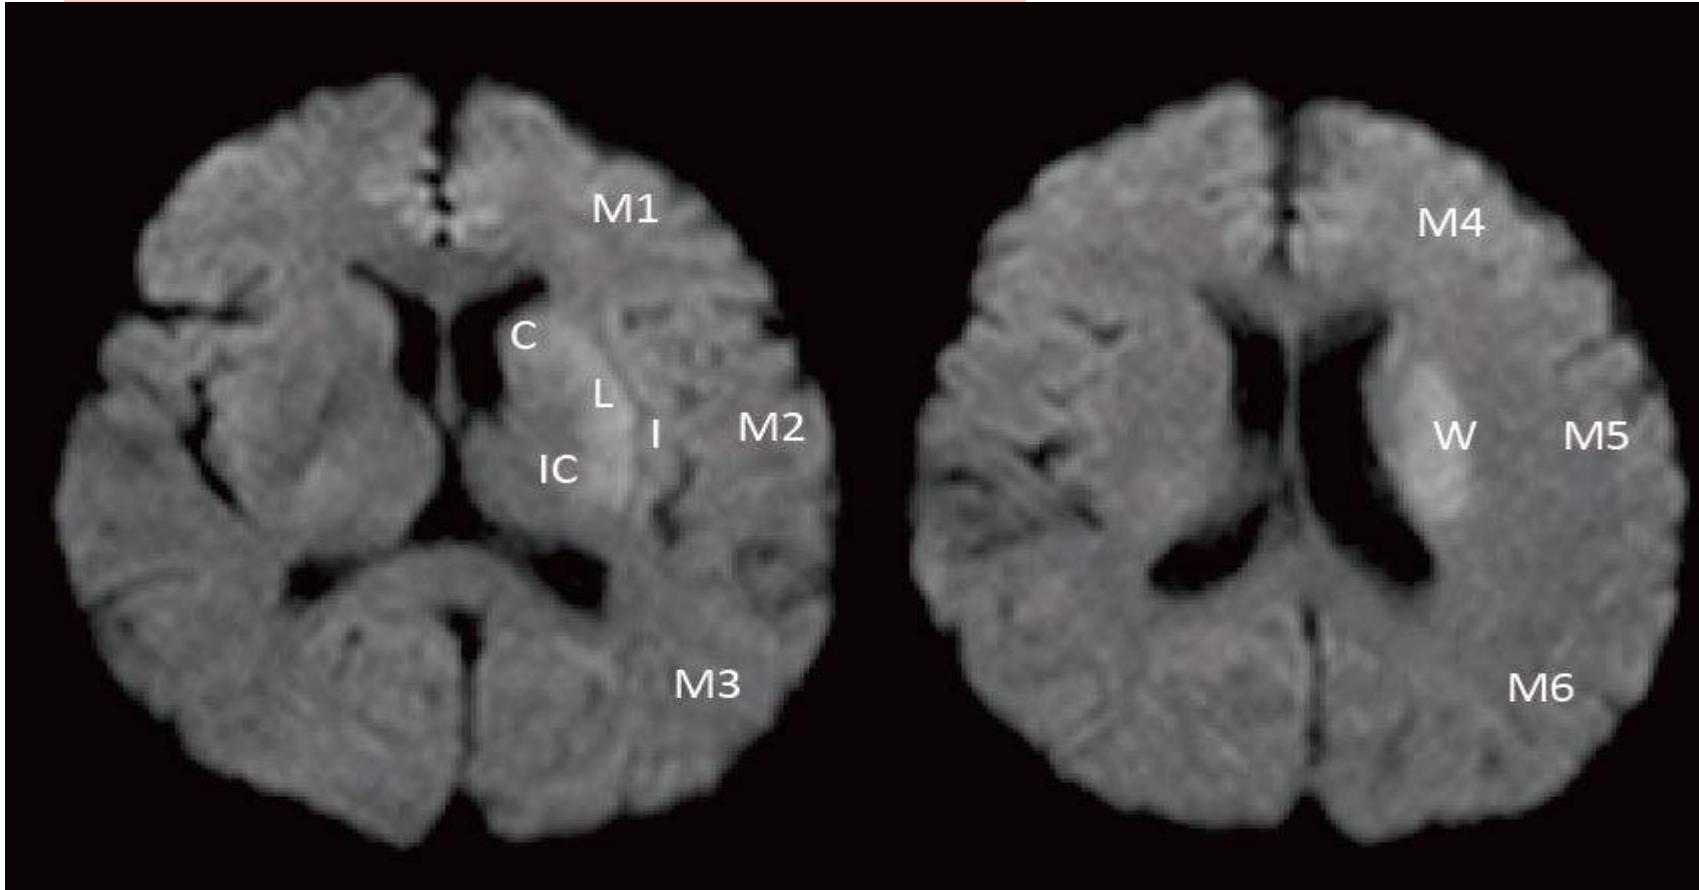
DWI ASPECTS is evaluated in 11 regions: 10 ASPECTS (Alberta stroke programme early CT score) sites and a white matter (W) lesion. If abnormal signals due to infarction are detected, the count is 0; if they are not detected, the count is 1. If no infarctions are ultimately observed, the total score is 11; if infarction is observed in all target regions, the total score is 0. C: caudate.; L: lentiform.; IC: internal capsule.; I: insular ribbon.; M1: anterior middle cerebral artery (MCA) cortex.; M2: MCA cortex lateral to the insular ribbon.; M3: posterior MCA cortex.; M4, M5, and M6 are anterior, lateral, and posterior MCA territories, respectively, immediately superior to M1, M2, and M3, respectively, rostral to basal ganglia.; W: white matter (corona radiate).
